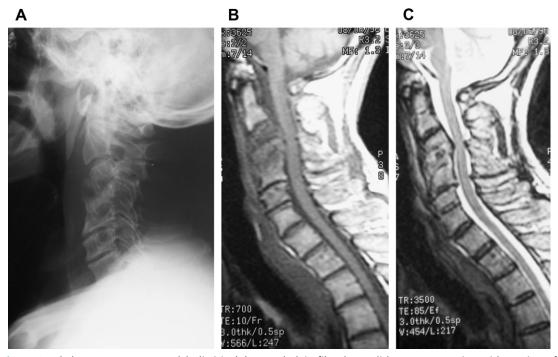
Staphylococcus aureus spondylodiscitis. (A) Lateral plain film shows disk space narrowing with erosion of the end plates at the C3-4 level. Also note C4-5 severe disk space narrowing and fusion related to prior infection. (B) T1 sagittal image shows decreased signal of C3 and C4 vertebral bodies with loss of the hypointense band of the adjacent end plates. Note obliteration of the C4-5 disk space. (C) T2 sagittal image shows increased signal intensity of the C3-4 disk space.
